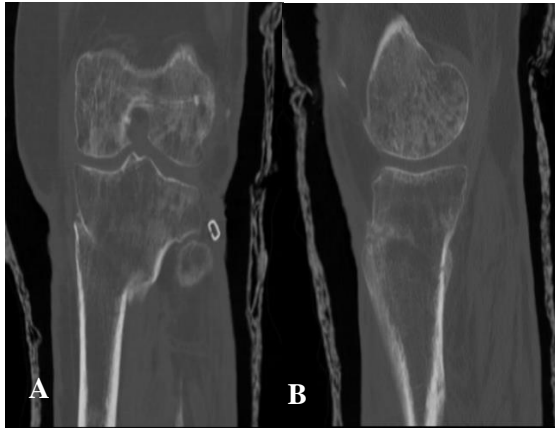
(A) AP, CT scan 6 months later, revealing fracture consolidation; (B) Lateral, CT scan 6 months later, revealing fracture consolidation.
